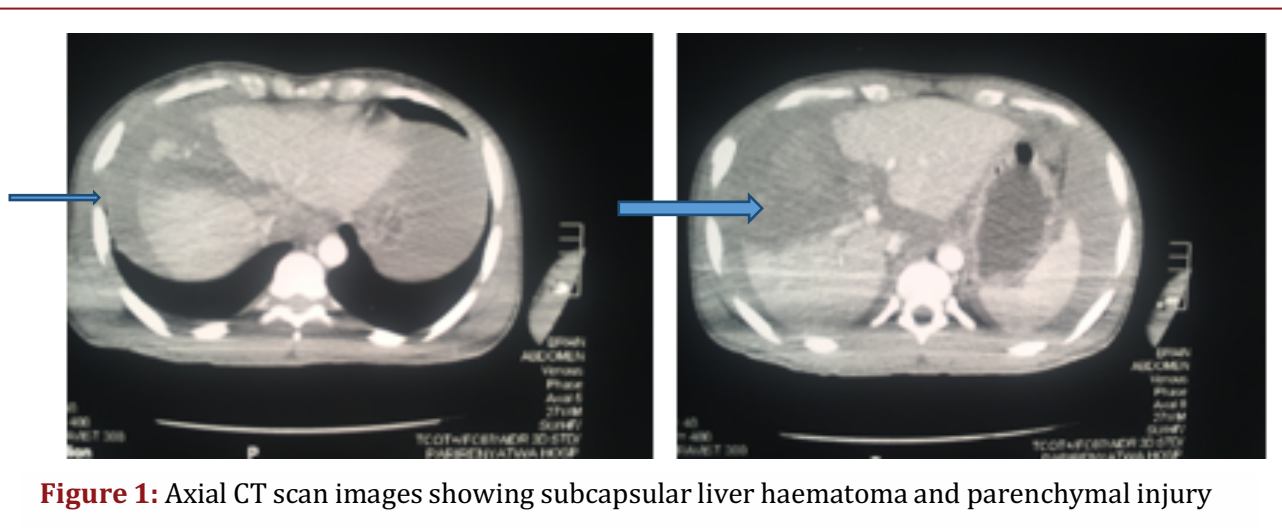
Axial CT scan images showing subcapsular liver haematoma and parenchymal injury
